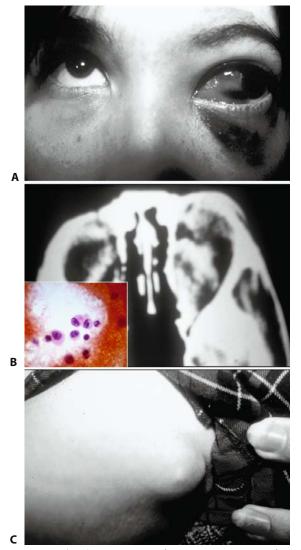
(A,B) Cutaneous melanoma metastatic to the orbits bilaterally. The predominant tumor load was in the left orbit, and, therefore, the left eye appears to be more proptotic. (B) The extraocular motility of the right orbit was full at the time of the CT scan. *Inset*: Melanoma cells obtained with FNAB. (C) Enlarged, melanoma-laden, left axillary lymph nodes.
